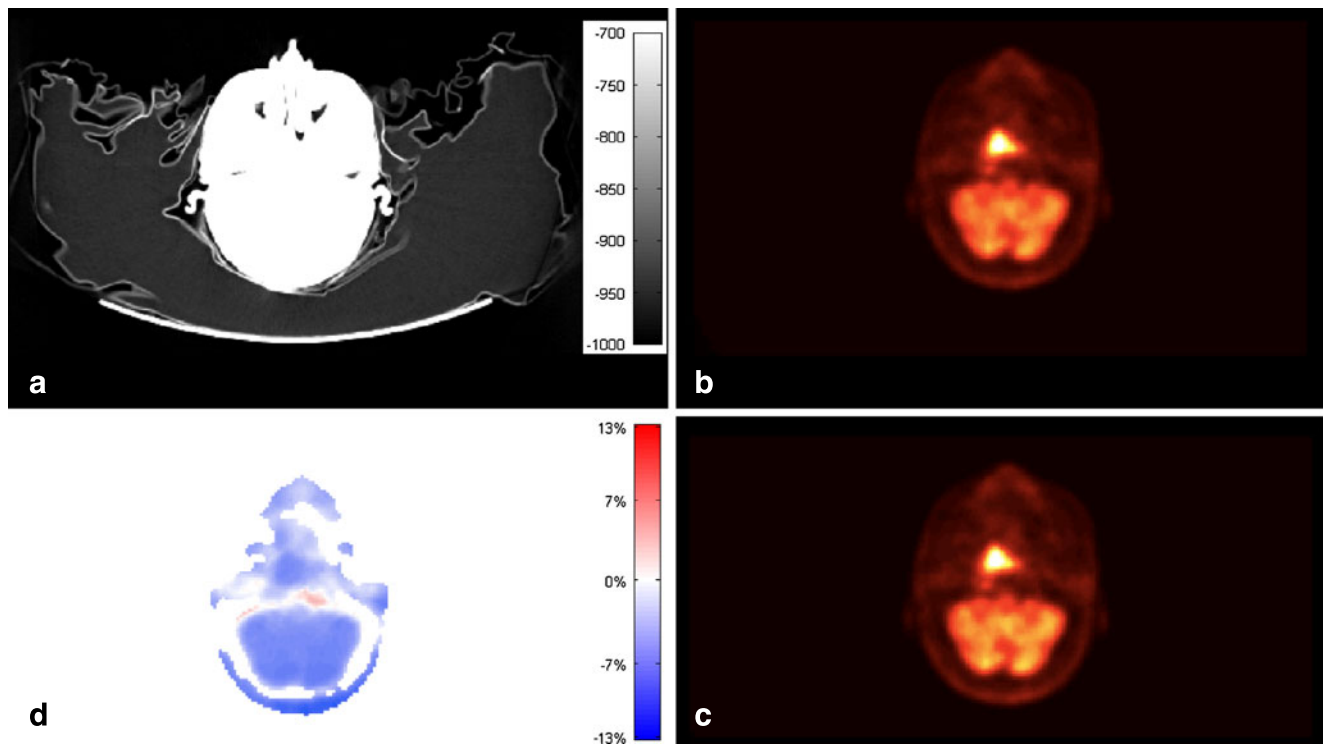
[^{18}F]FDG imaging of a patient with a neck lesion, axial images: (a) CT with vacuum mattress (in HU), (b) PET following origCT-AC, (c) PET following modCT-AC, (d) difference (percent, $\pm 13\%$ max) image of b and c
